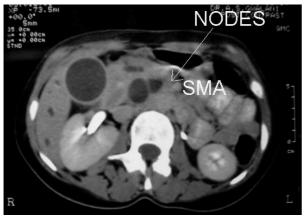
CT scan of the abdomen showing a dilated bile duct and small nodes adjacent to the superior mesenteric artery (SMA).
